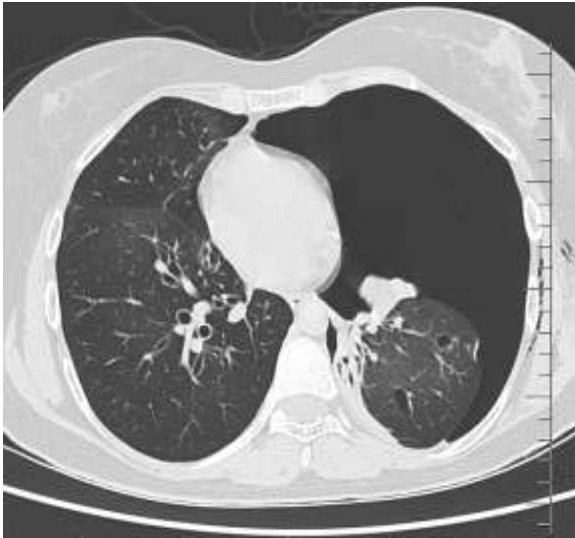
CT thorax - representative image showing large left pneumothorax and collapsed lung
